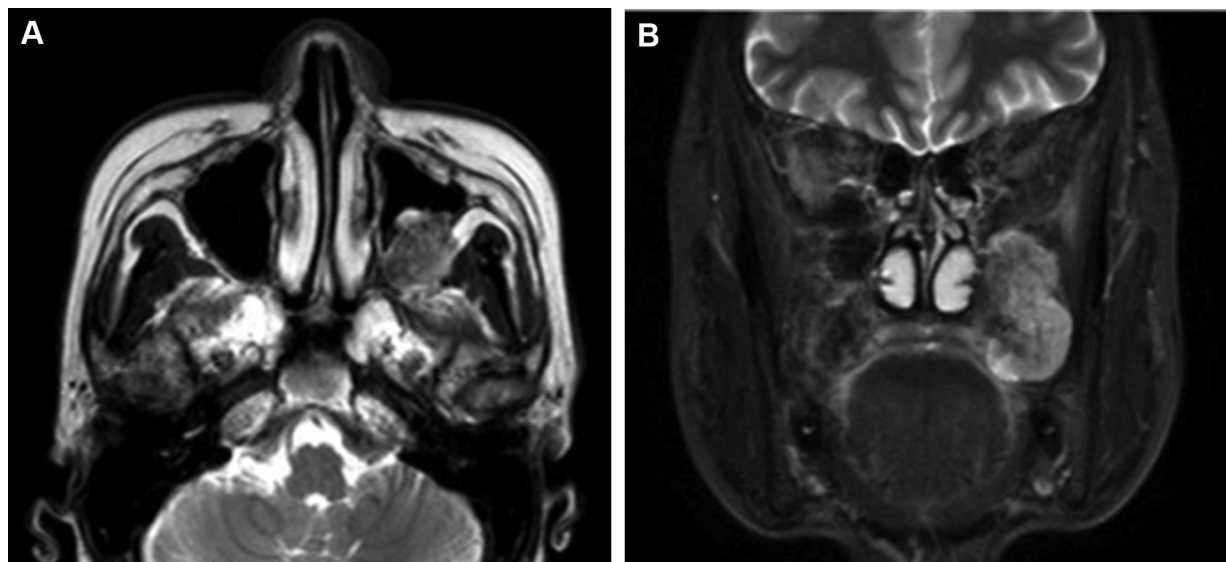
Magnetic resonance imaging findings. A, Axial T2-weighted and B, coronal short T1 inversion recovery images depicted a 43- × 22- × 21-mm mass with high signal intensity. The mass was located at the posterior of the maxillary sinus and extended to the pterygo-maxillary fossa.
